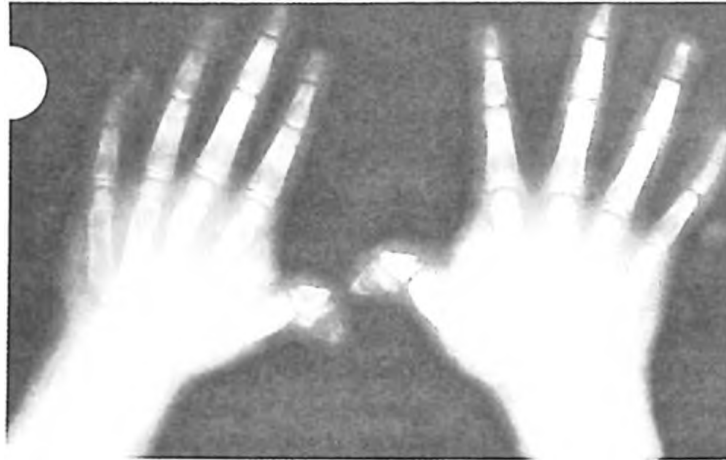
Radiographs of the hands showing bilaterally abnormal angulation of the thumbs and the right split distal phalanx.
